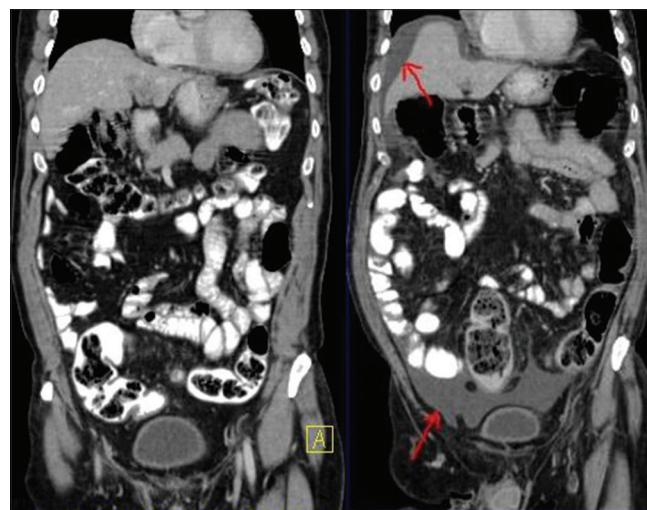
Comparative computed tomography scan images (base line on the left side and post therapy on the right side) show new development of ascites as a complication of portal vein thrombosis
